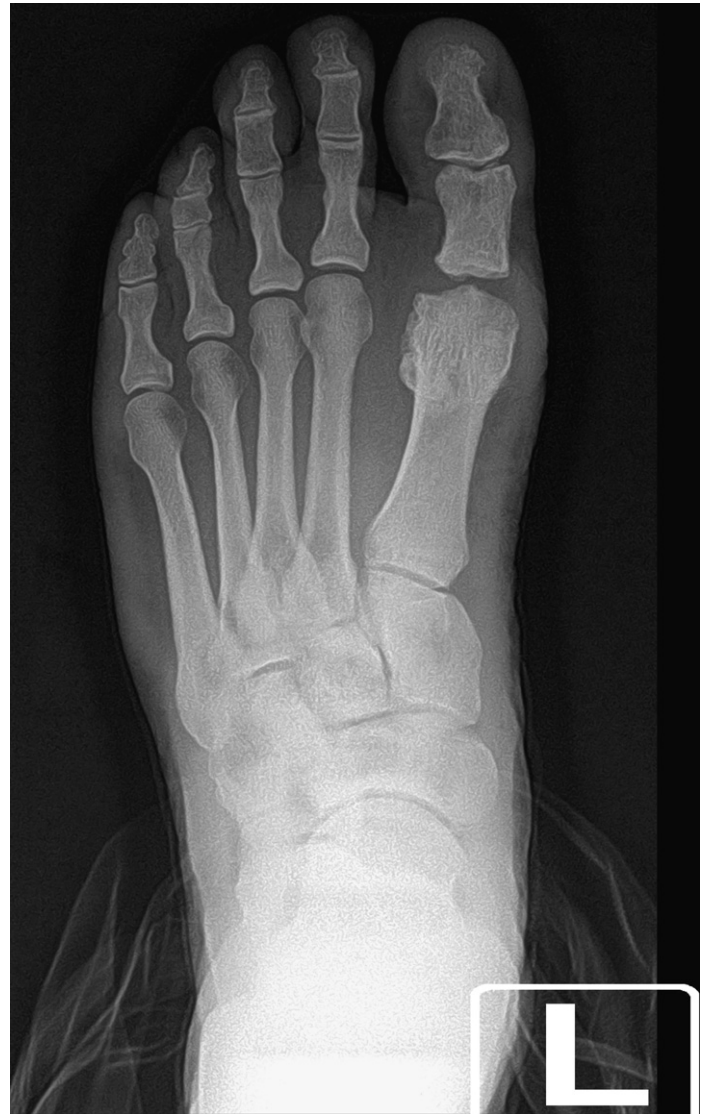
Resectional arthroplasty. Postoperative dorsal-plantar radiographic view demonstrating result of resectional arthroplasty of first metatarsophalangeal joint.
